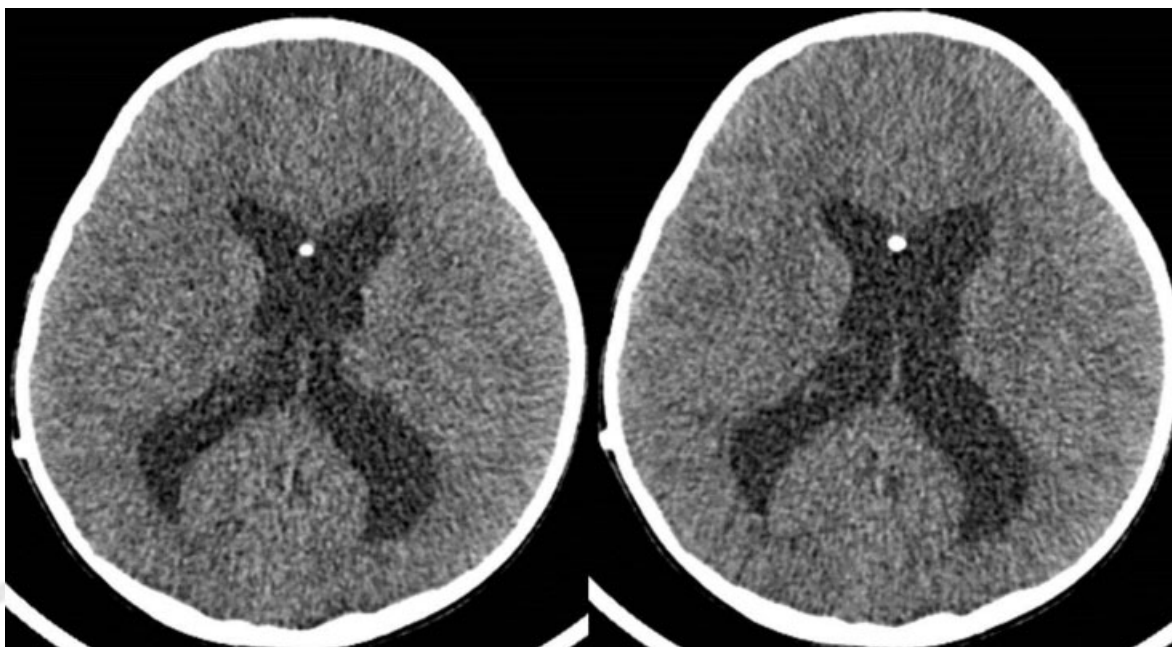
Brain computed tomography scans revealed a moderate ventricular dilatation.
